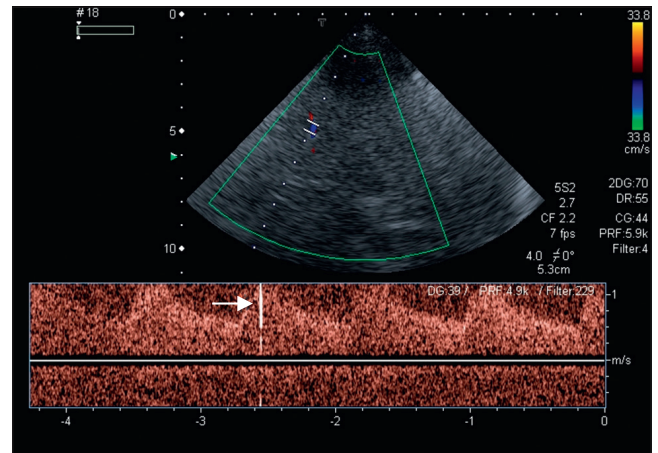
Transcranial Doppler. Microbubble artifact (spike) detected in the middle cerebral artery (arrow)
